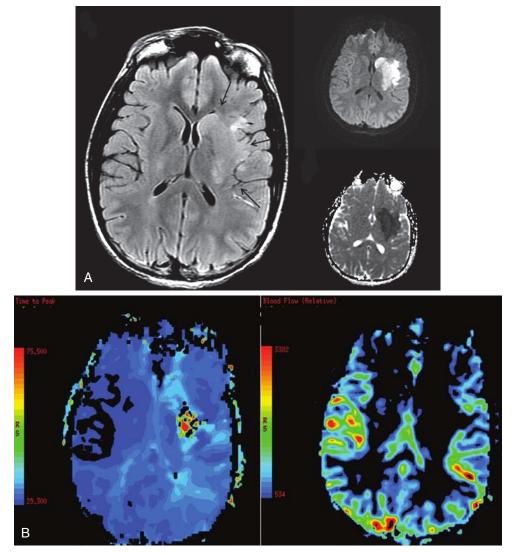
Patient presenting with new-onset neurologic symptoms; rule out stroke. A, *Left*: Axial fluid attenuation inversion recovery (FLAIR) image at the level of the basal ganglia delineates relative hyperintensity in and swelling of the left basal ganglia and adjacent insular cortex *(arrows). Right, top and bottom*: Diffusion-weighted imaging (DWI) and apparent diffusion coefficient (ADC) images at the same level demonstrate hyper- and hypointensity, that is, restricted diffusion. Acute stroke. B, Two maps: Time to peak *(left)* and cerebral blood flow *(right)*, from the perfusion study obtained. Note the asymmetry between the two cerebral hemispheres.
